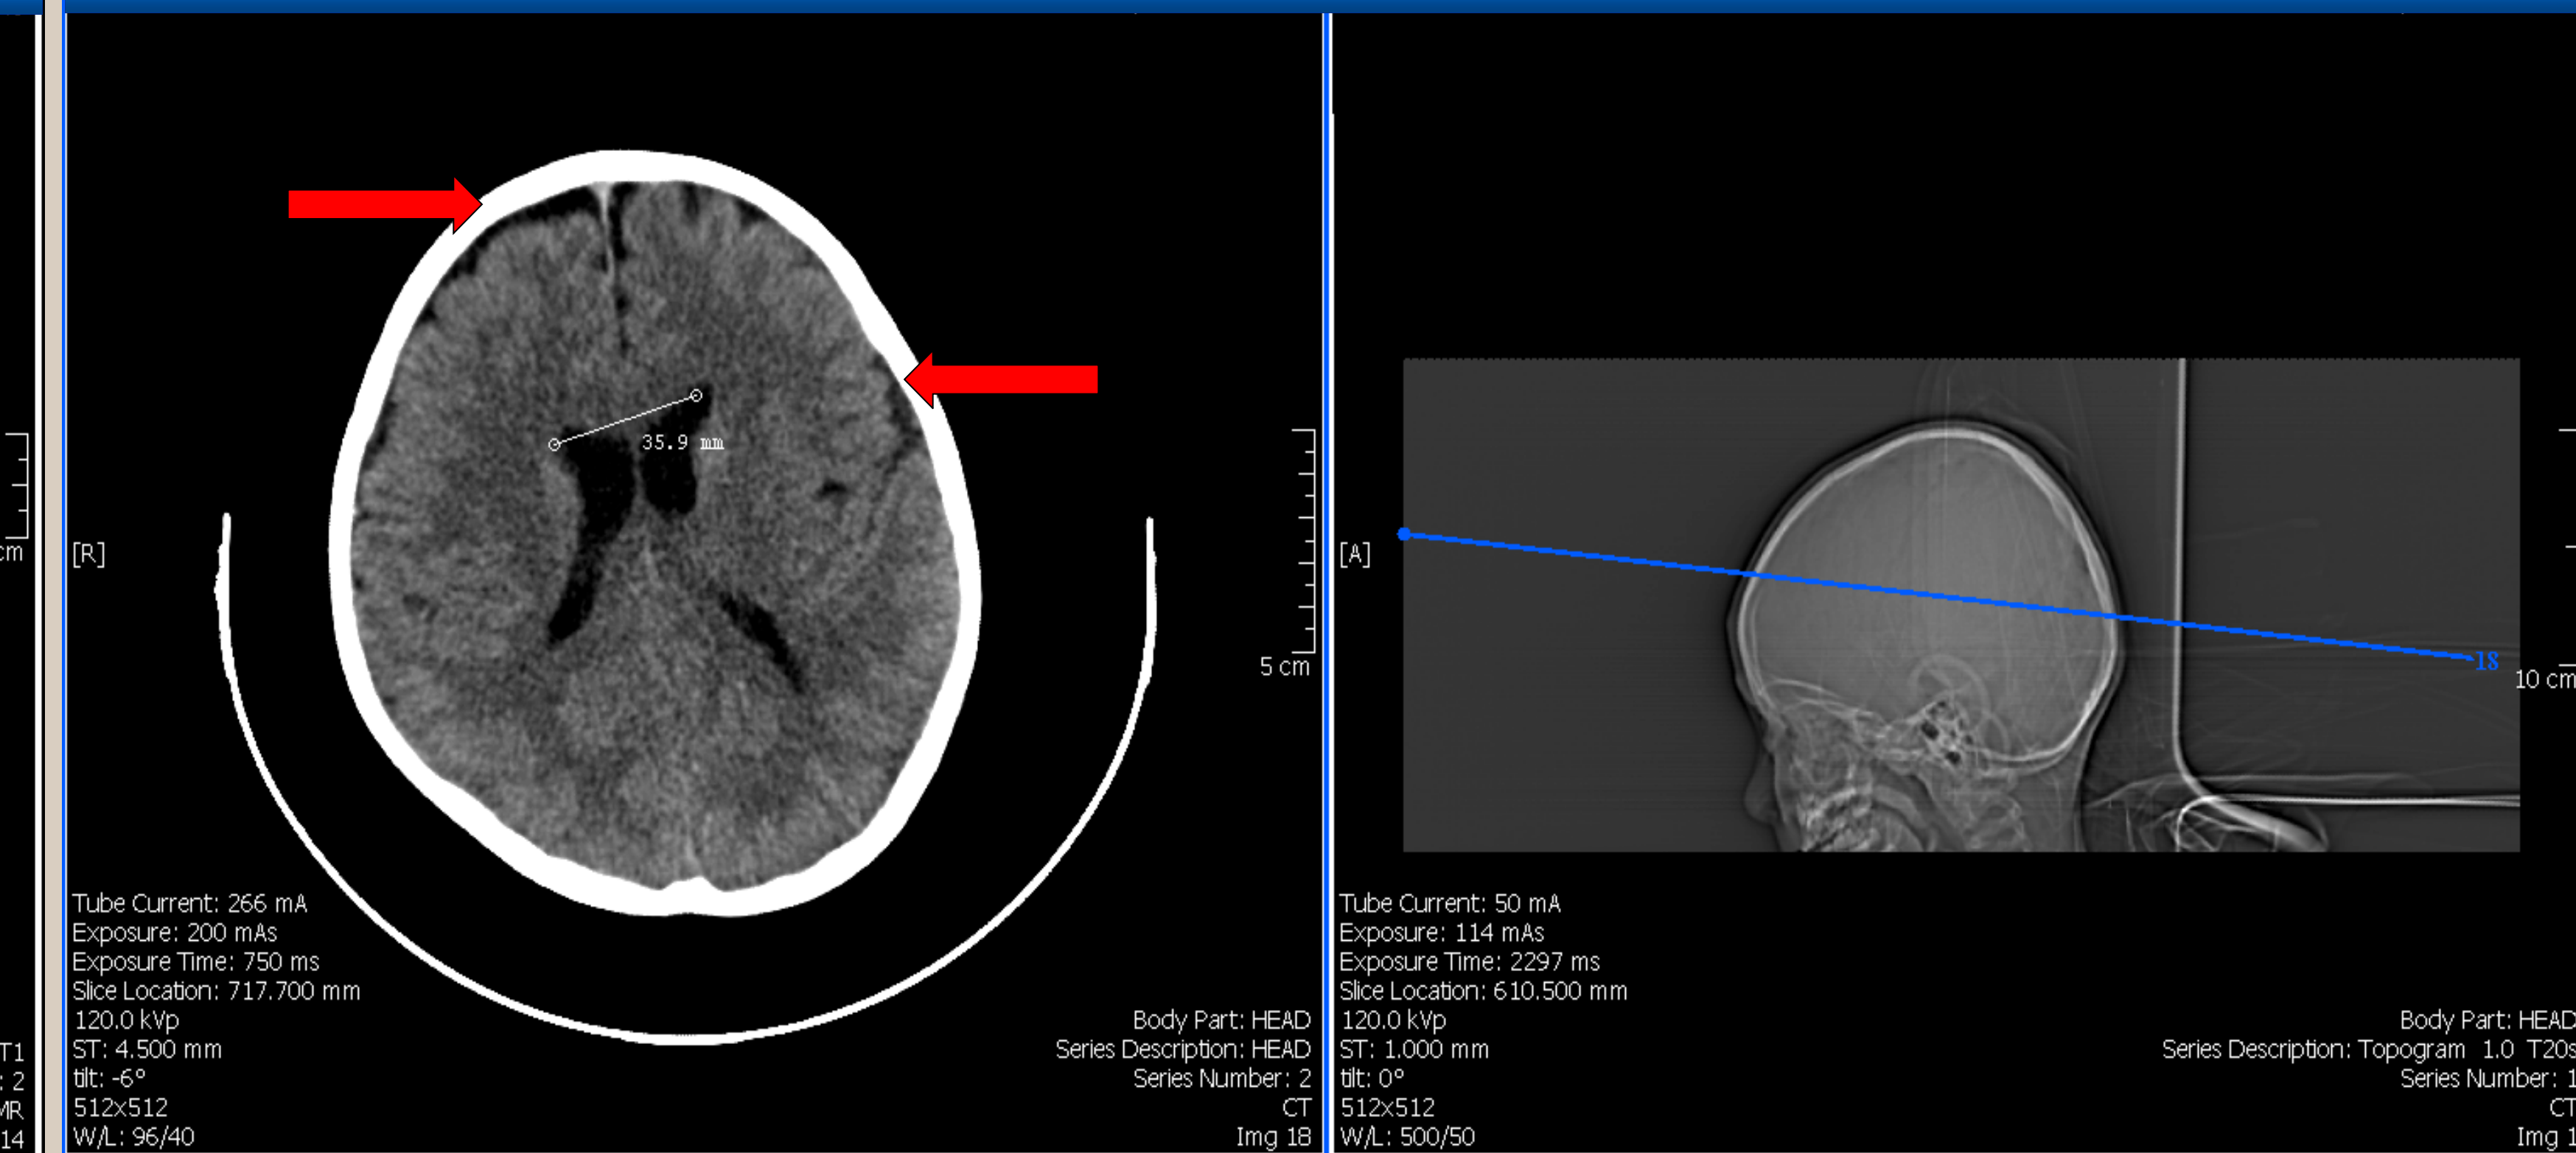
CT scan at time of admission for PDPH showing frontal parietal regions with less CSF (red arrows)
